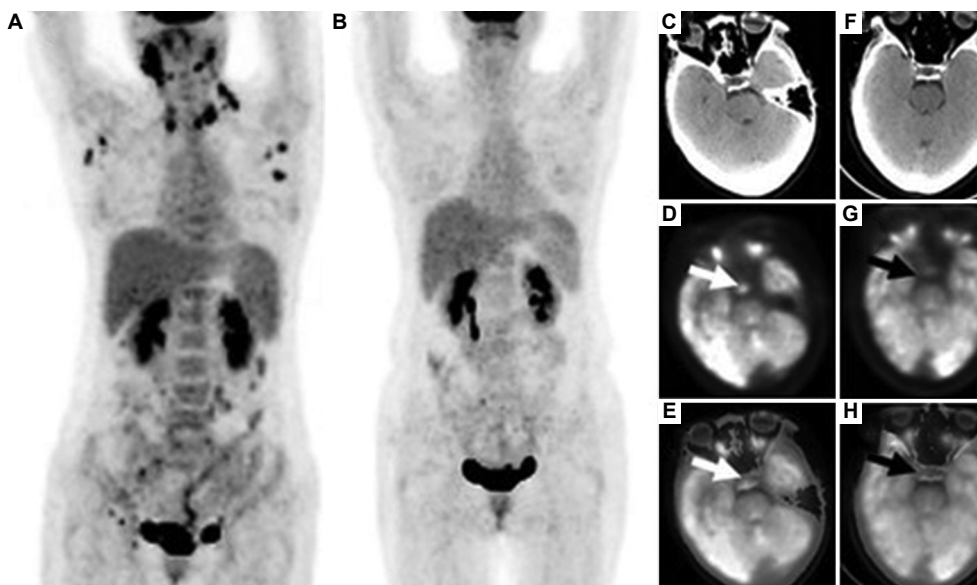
Whole-body PET (MIP) of a patient with Langerhans cell histiocytosis, demonstrating multiple hypermetabolic lymph nodes (SUV_{max} 4.4–13.2) before treatment (A) with resolution post-chemotherapy (B). Pituitary uptake is also visible on PET, CT, and fused PET/CT images (white arrows, SUV_{max} 6.0) before treatment, decreasing after chemotherapy (black arrows, SUV_{max} 3.6), highlighting therapy-related changes in metabolic activity. This figure is adapted from Ju *et al.*,⁵ available under a Creative Commons Attribution (CC BY 3.0) license.
